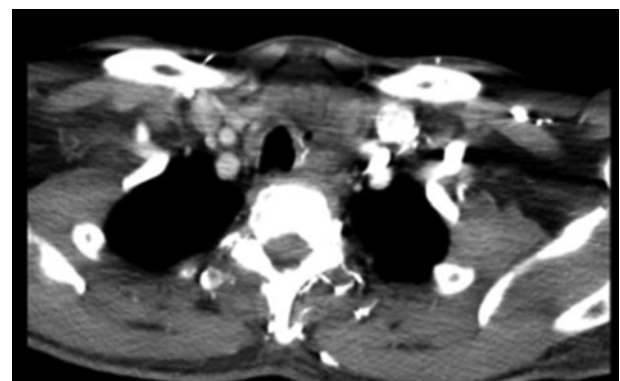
Case 2. Axial plane computed tomography scan showing sinus developed from trachea into thyroid following eight months of tyrosine kinase inhibitor therapy which self-resolved.
